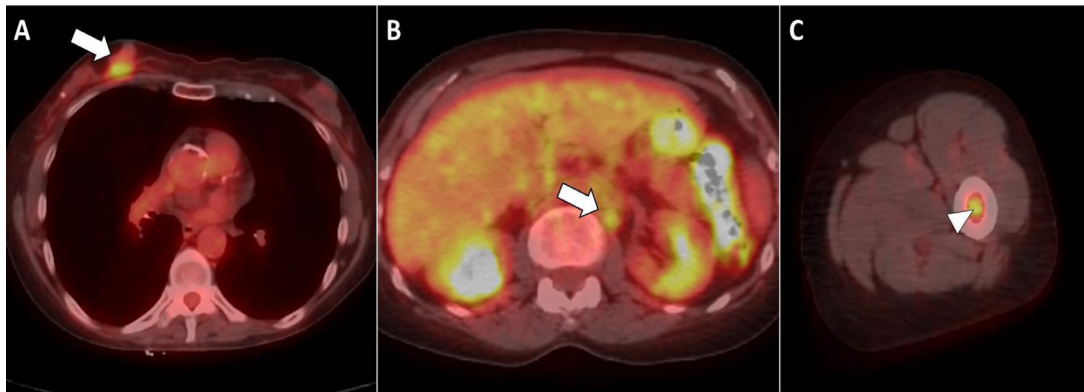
FDG-PET/CT study for initial staging of lymphoma. (A) Axial image at the level of the right breast mass shows uptake with SUV max 3.2 (arrow). (B) Additional focus of uptake noted in left paraortic lymph node measuring 1 cm with SUV max 2.9 (arrow). (C) Focal uptake also noted in bone marrow of the mid shaft of the left femur with SUV max 3.2 (arrowhead).
